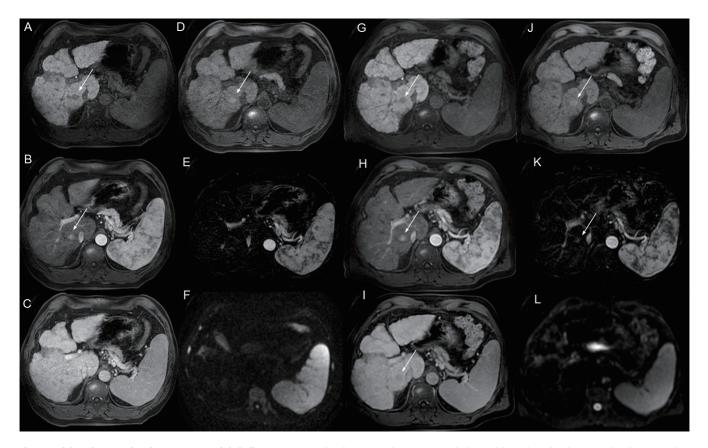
Axial MR images showing a 17 mm nodule in liver segment 6. (A–C) It appears hypointense in the hepatobiliary phase (HBP) compared to the surrounding parenchyma (arrow in A) but was not visible in the portal phase (arrow in C). (D–E) The nodule appears moderately hyperintense in the arterial phase (arrow in B) but this appearance was found to be related to its hyperintensity in the precontrast T1-weighted images (arrow in D) rather than a true hypervascularization, as demonstrated by the arterial subtraction images (E). (F) No significant restriction was noted with diffusion-weighted imaging (DWI). (G–J) Follow-up axial MR images of the same HBP hypointense nodule performed after 6 months (arrow in G) demonstrated the appearance of the typical hepatocellular carcinoma (HCC) imaging features, i.e. the arterial phase hyperenhancement and the portal venous washout (arrows in H and I, respectively); in particular, the arterial hypervascularization was now evident in the subtraction images (arrow in K) and no longer attributable exclusively to baseline hyperintensity in T1-weighted images (arrow in J). (L) Interestingly, DWI did not have a significant diffusion restriction corresponding with the lesion.
